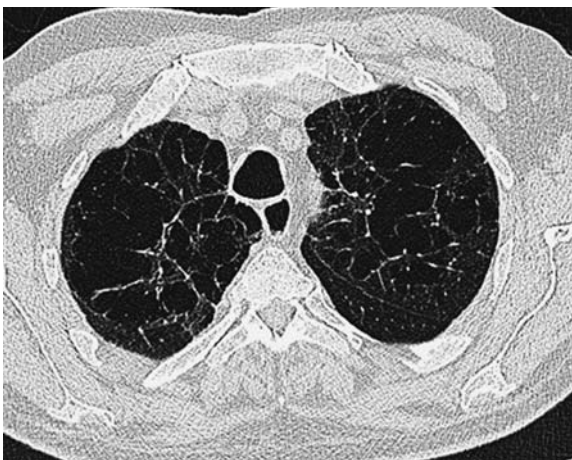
Thin-section computed tomography through the upper zones in a patient with severe centrilobular emphysema. Many of the low attenuation lesions of emphysema appear to have a well-defined wall, and the appearances may be mistaken for those seen in “end-stage” Langerhans’ cell histiocytosis
